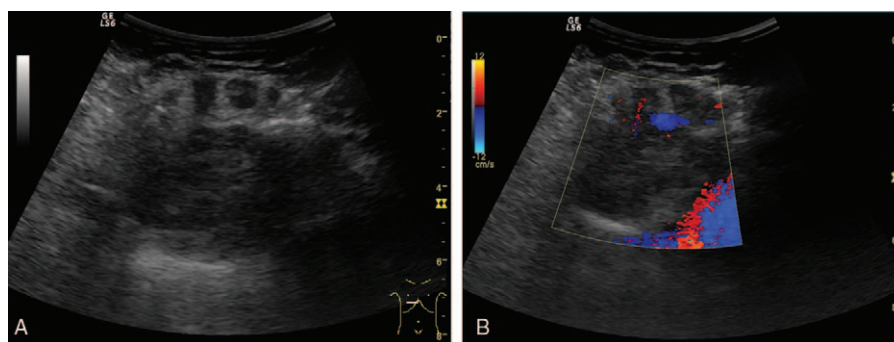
A, Right parasternal hypoechoic, slight inhomogeneous lesion (mediastinal lipoma). B, Hypo vascularized lipoma in color Doppler mode.
